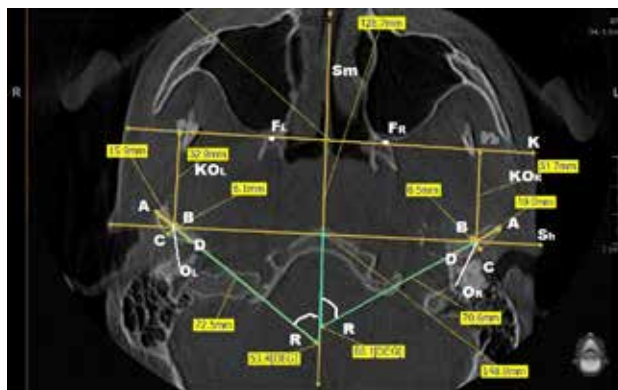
CT parameters measurement scheme of TMJ in axial projection
